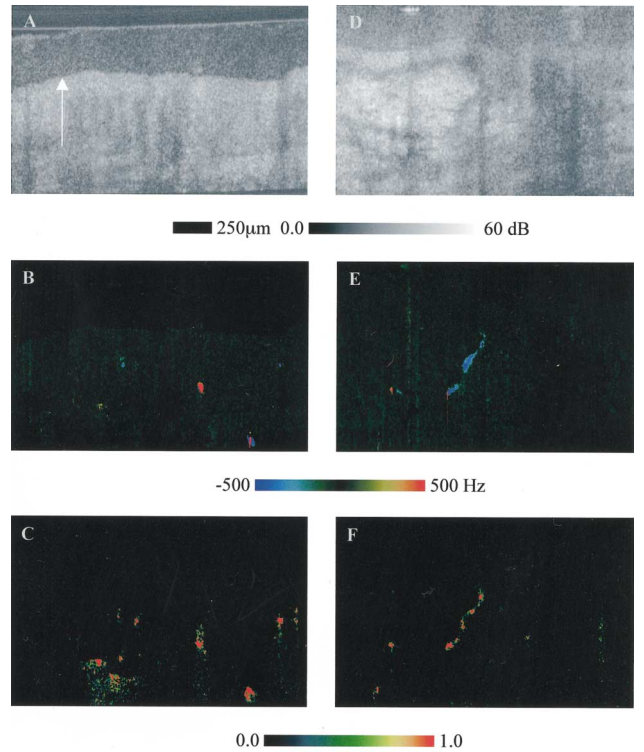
Tomographic images of a left upper extremity PWS. A, D, Structural images; B, E, Doppler-shift (blood flow velocity) images; C, and F, normalized variance of flow velocity. Images A–C are taken from the palm-side surface of the ring finger. Images D–F are taken from the forearm. The arrow in image A indicates the boundary between the stratum corneum and the epidermis.
